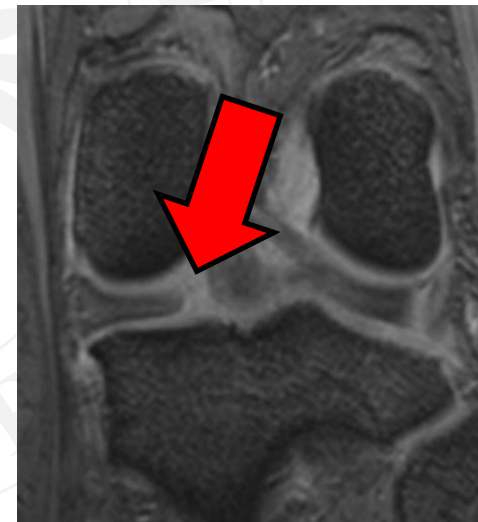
MRI coronal plane of the left knee. Red arrow indicates a medial meniscus posterior root tear.
